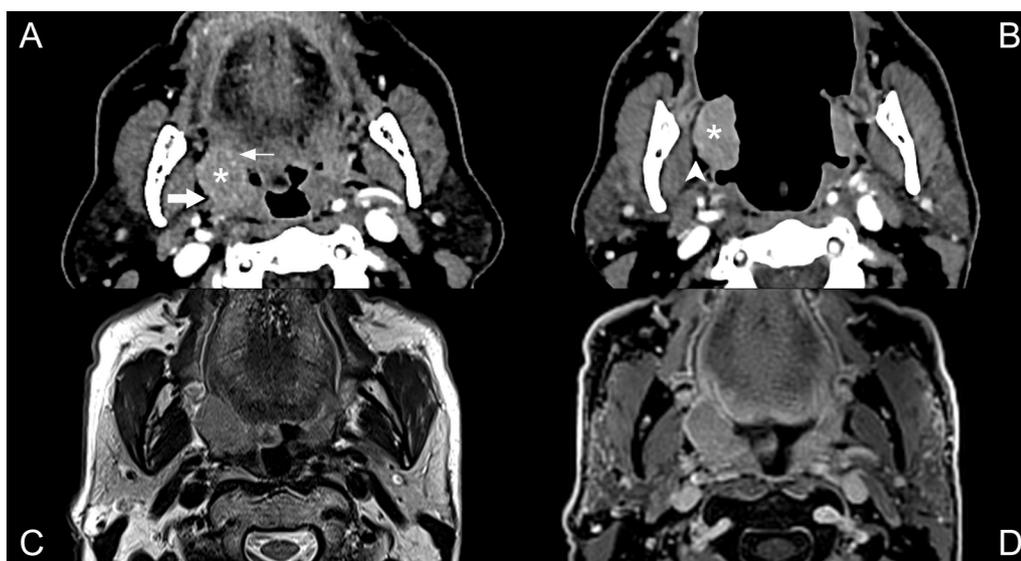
T2 staged tonsillar carcinoma with typical concordant aspect in CTconv, CTmote, and MRI. CT with injection in axial section centered on the oropharynx, conventional closed mouth (A), in MOTE maneuver (B). MRI in T2 (C) and T1 weighted axial section with gadolinium injection and fat saturation (D). A 73-year-old male, former smoker with squamous cell carcinoma cT2N0M0 (pT2) of the right tonsil. In image A, an asymmetry of the tonsils is distinguished with a nodular contrast enhancement of the right tonsil (*). The edges are not very well limited with the glosso-tonsillar sulcus in front (fine arrow); the lateral pharyngeal wall and the styloglossus muscle behind (broad arrow). In image B the lingual protraction stretches the structures of the oropharynx and distends the glosso-tonsillar sulcus path. The tonsillar compartment is isolated and the absence of invasion of the tongue base and the styloglossus muscle appears certain. The fatty border separating the medial pterygoid muscle from the tumor is better visualized (arrowhead) than in image A. The tumor enhancement is greater with CTmote (CNR = 4.3) than in CTconv (CNR = 2.4). MRI images (C, D) appear to be of good quality on both sequences.
